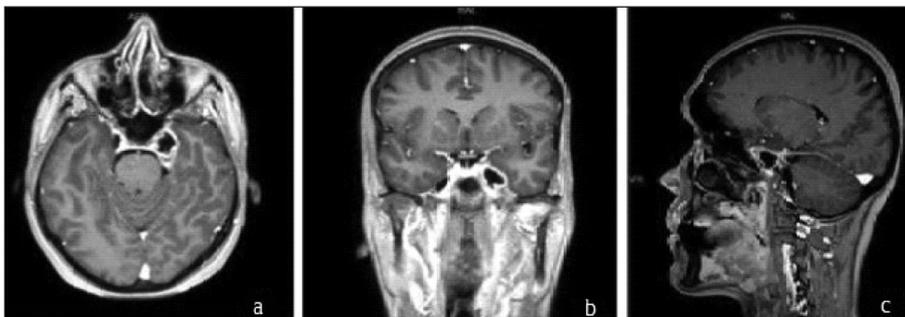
At the 7th month after the treatment, a regressed trigeminal schwannoma adjacent to the cavernous sinus is observed in the contrast-enhanced T1 cranial magnetic resonance imaging axial (a) and coronal (b) and sagittal (c) images.
